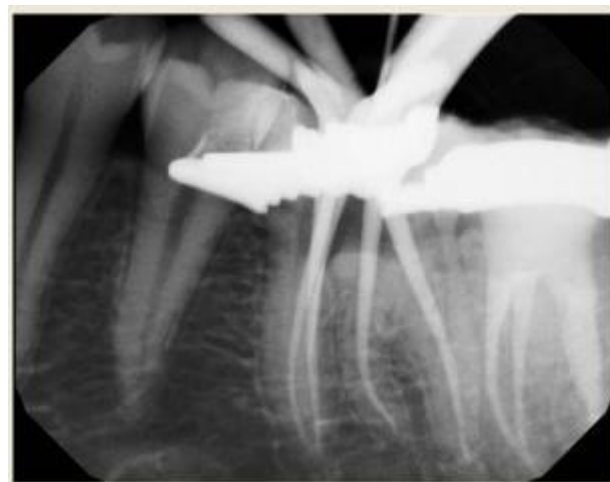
Showing working length determination with the help of radiograph
